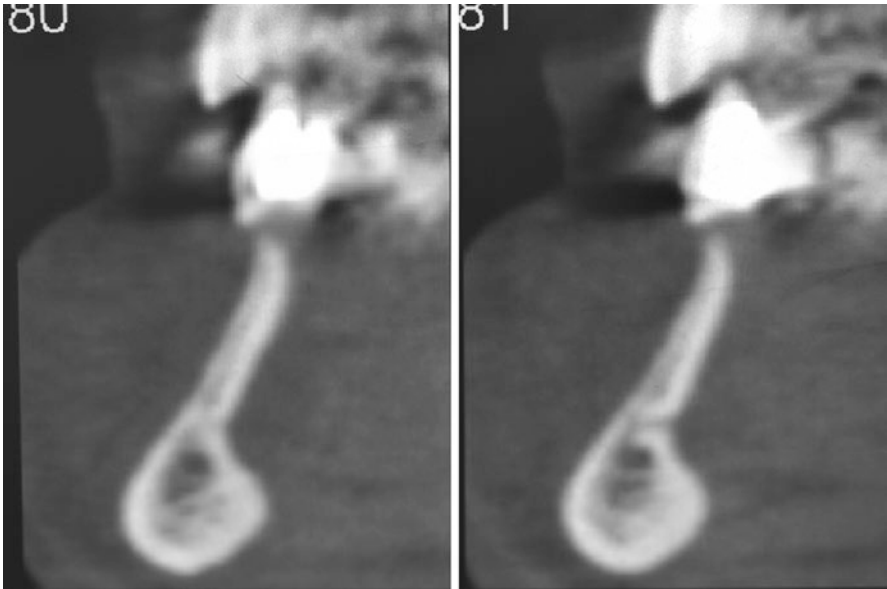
Cone beam CT showing the considerable discrepancy between panoramic radiographs and cone beam CT: high knife ridge with a thickness of less than 3 mm but a bone height of more than 13 mm. Typical high knife ridge (D1 bone) suitable for double Diskimplants®. The remaining natural teeth are maintained by just a thin shell of alveolar bone. Extraction of natural teeth is particularly challenging because as much surrounding bone as possible must be preserved
